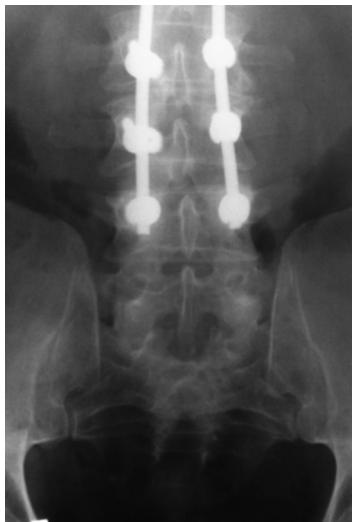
Preoperative radiography demonstrating spina bifida occulta on the first sacral segment
